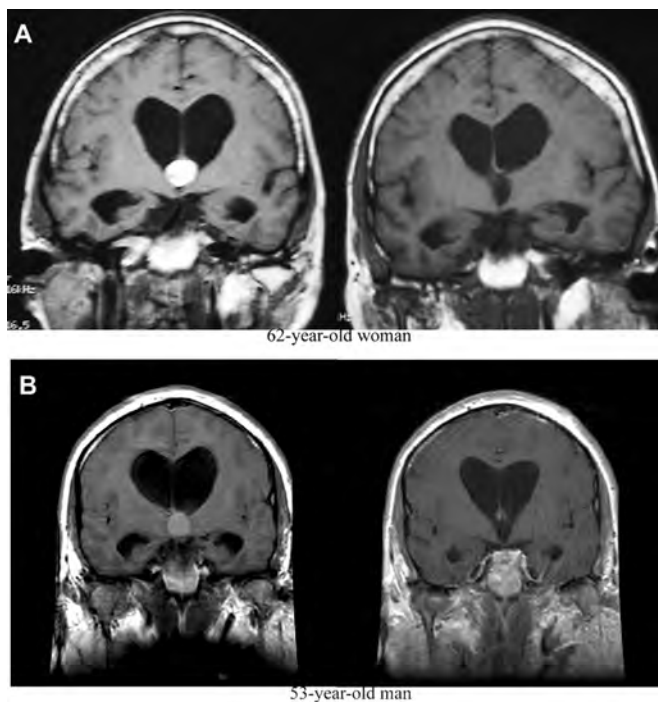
Pre-operative (left) and post-operative (right) coronal T1 weighted MR images of endoscopic resection of colloid cysts. The coronal images are used for pre-operative assessment of trajectory through Foramen of Munro to colloid cyst. When either a left or right trajectory provides adequate exposure to the cyst as in the case of this 62-year-old woman (A), then a right sided trajectory is chosen. The image on the right demonstrates a complete resection of the colloid cyst. In this case of a 53-year-old man (B), a left sided approach provided a better trajectory through an already enlarged Foramen of Munro.
